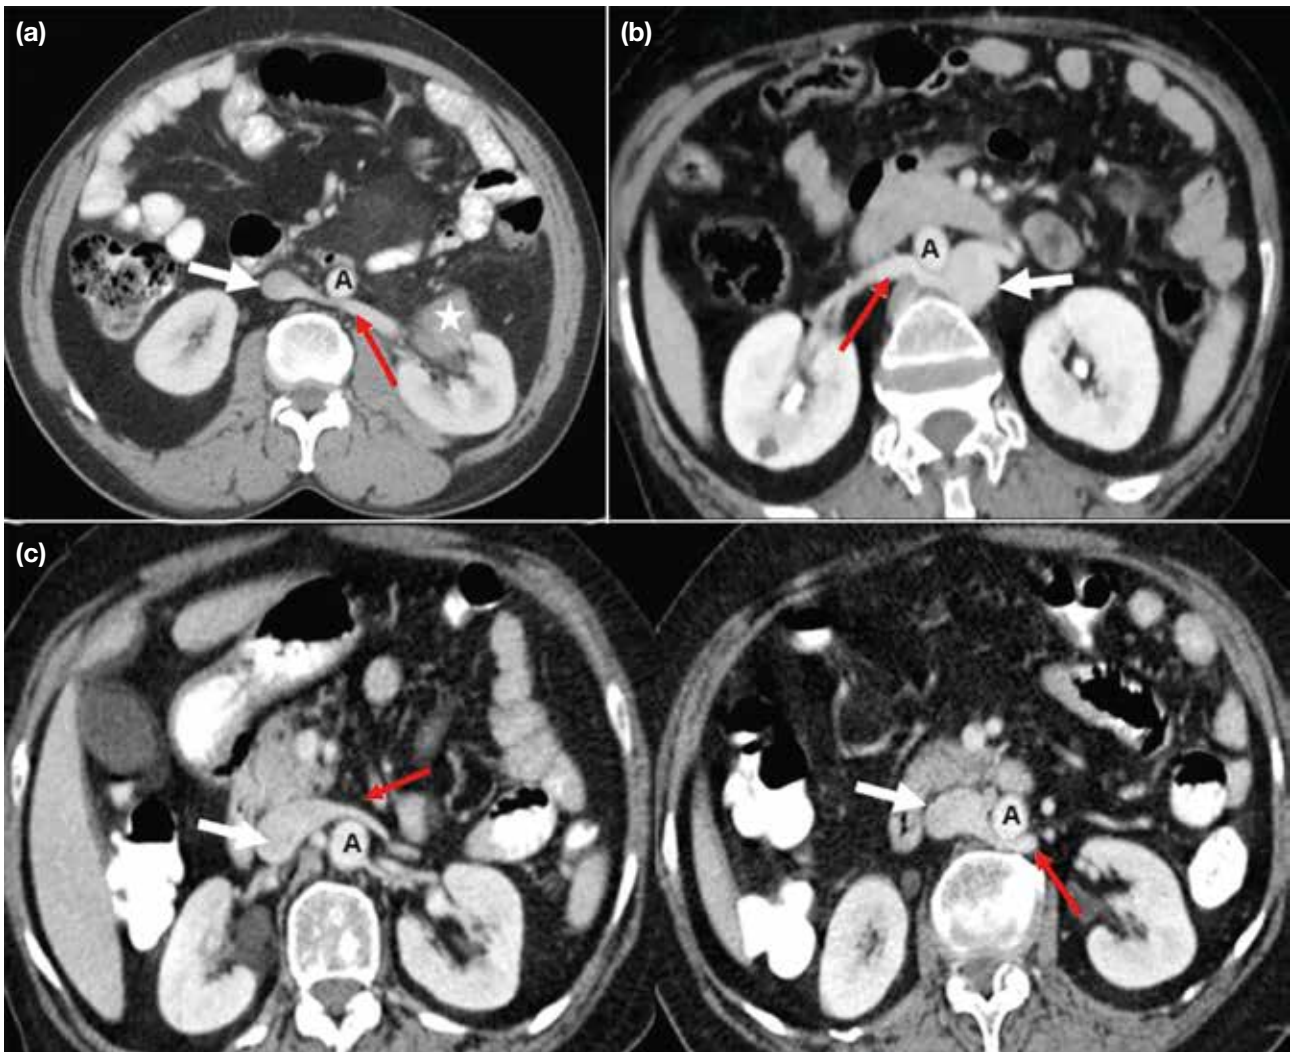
Contiguous axial contrast-enhanced computed tomography images showing anomalous renal veins. (a) Retroaortic left renal vein (red arrow) posterior to the aorta, draining into the normal right inferior vena cava (IVC) [white arrow] in a patient with abdominal liposarcoma (star). (b) Retroaortic right renal vein (red arrow) draining into the left IVC (white arrow). (c) Circumaortic left renal veins (red arrows) passing anterior and posterior to the aorta, draining into the right-sided IVC (white arrows). Abbreviation: A = aorta.
